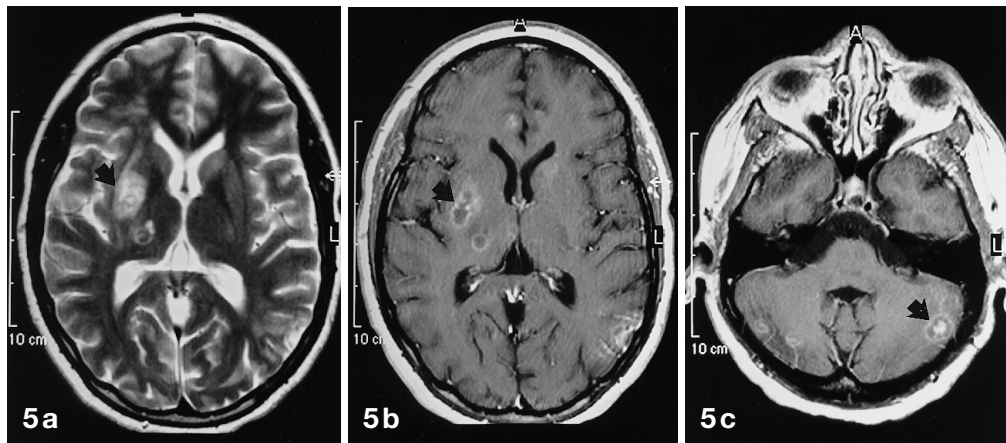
a-c. Toxoplasma encephalitis. a Axial T2-weighted (TSE 2870/120) MR image in a 32-year-old black woman with AIDS shows two lesions of high signal intensity (*arrow*) in the basal ganglia, caput nuclei caudati, and frontal and occipital lobes. b Axial contrast-enhanced T1-weighted (SE 639/15) MR image at corresponding level shows the lesions with ring-like enhancement and irregular margins. c Axial contrast-enhanced T1-weighted (SE 639/15) MR image at a lower level shows multiple additional lesions with a "target" appearance (*arrow*)
